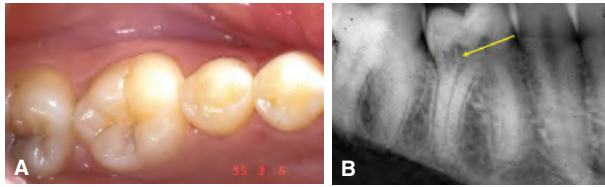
A. Crown of a mandibular first molar with no external signs of resorption. B. Radiograph of the tooth pictured in A showing an irregular radiolucency extending from the distal cervical region into the crown and adjacent to the pulp space but separated by a radiopaque line (yellow arrow).
